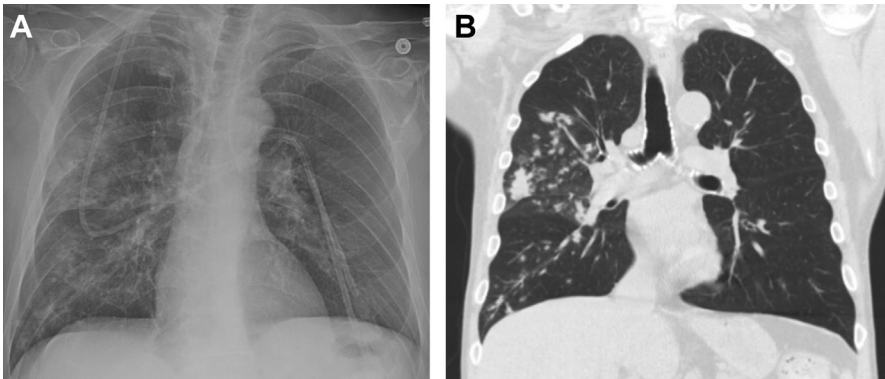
Varicella pneumonia in a 72-year-old man with multiple myeloma status postautologous transplant complicated. (A) Frontal radiograph demonstrates multiple nodules in the right lung. (B) Coronal chest CT demonstrates a focal area of nodular consolidation with clustered adjacent centrilobular micronodules. Fewer micronodules are present in the lower lobe. (Courtesy of Shamus Moran, MD, Seattle, Washington.).
